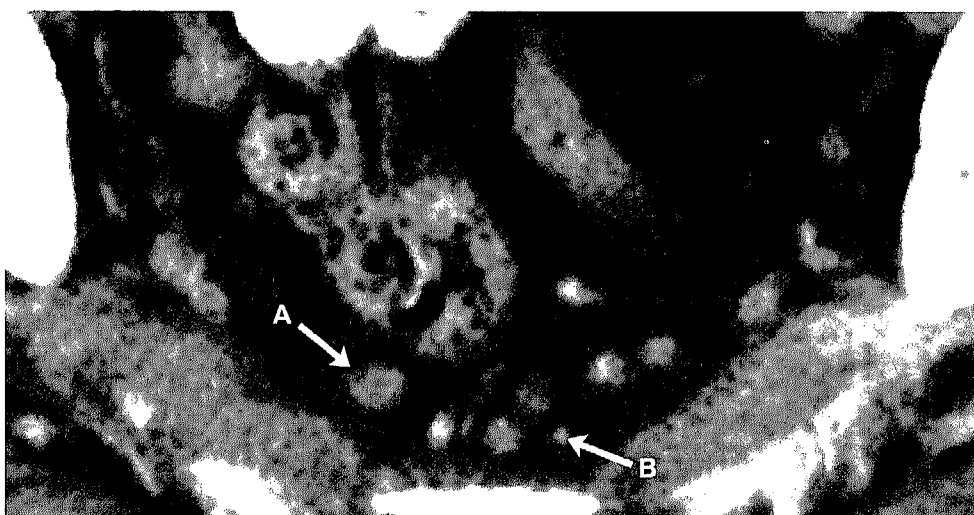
Corresponding CT scan of the same female patient as Figure 4.6A. Discrimination between the involved lymph node (A) and the reactive lymph nodes (B) is impossible, due to lack of contrast resolution.
